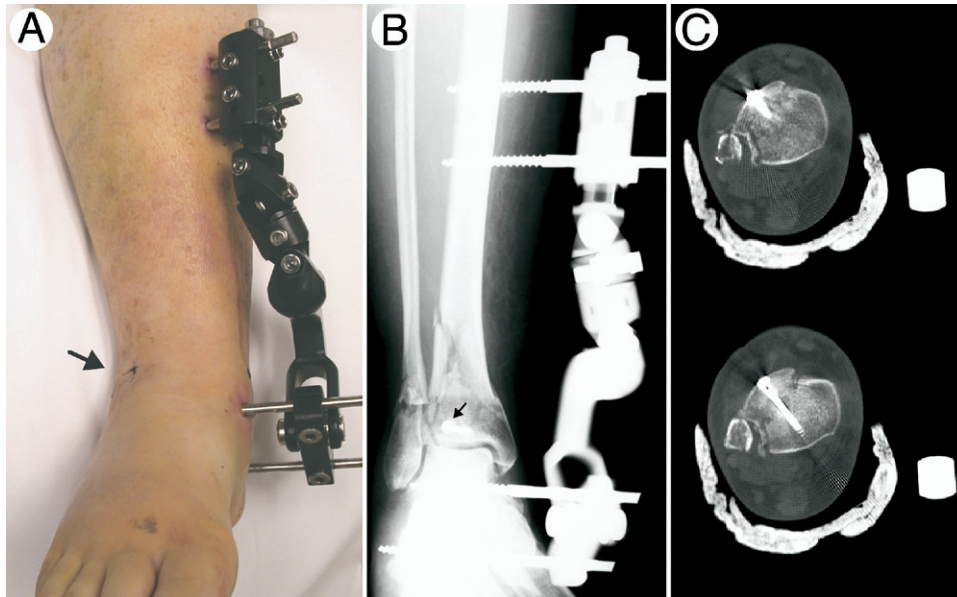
Same patient as [Figure 2](#), demonstrating temporary stabilization with an external fixator. (A) Clinical photograph demonstrating temporary medial external fixator. (B) Radiographs with external fixation in place. The medial monorail used in this case was not ideal because half pin in the talar neck is located very close to the ankle joint capsule, and is at risk for development of a septic joint should this pin become infected. A delta configuration medial external fixator is a more appropriate choice. In this case, a periarticular percutaneous screw was placed anteriolaterally (*arrow*), though not necessary to be placed during the temporary external fixations setting. Ideally, definitive fixation is placed once the soft tissues have recovered and the external fixator is removed. (C) CT after external fixation allows for evaluation of the temporary reduction.
